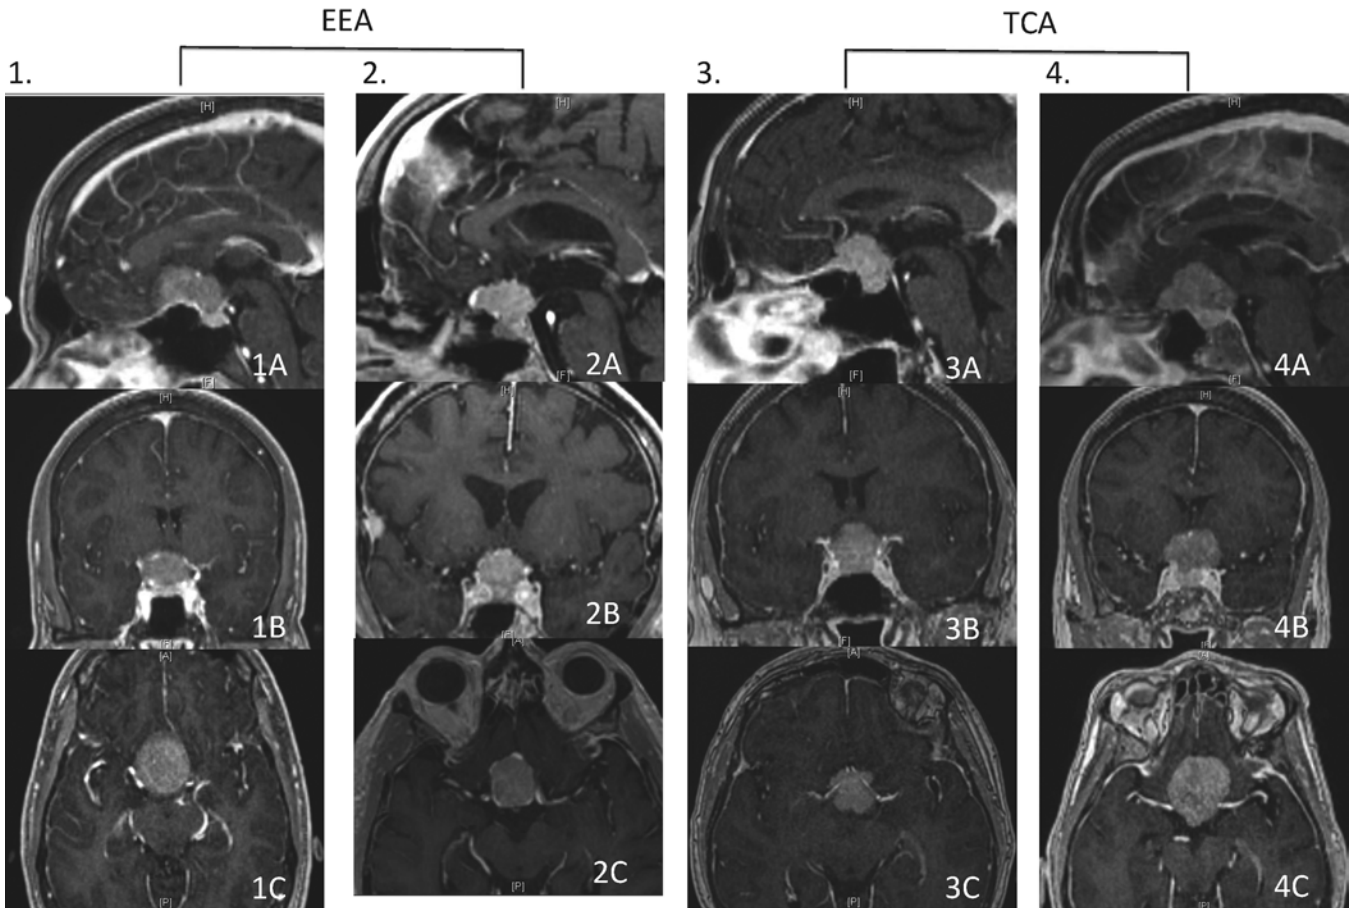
Representative MR images of TS and PS meningiomas considered accessible by either a TCA or EEA. Sagittal (A), coronal (B), and axial (C) T1-weighted postcontrast MR images through TS and PS meningiomas of 4 representative patients. EEA was performed in Cases 1 and 2, and TCA was performed in Cases 3 and 4.
